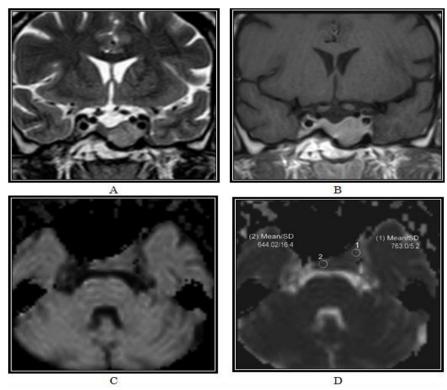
A- Coronal T2WI revealed hyperintense sellar & left para-sellar lesion. B- Coronal T1WI Post Gd DTPA revealed homogeneous enhancement of the lesion. C- Axial DWI displayed isointense to the brain parenchyma. D- ADC map revealed isointensity of the lesion with ADC value 0.7×10^{-3} mm²/s.
